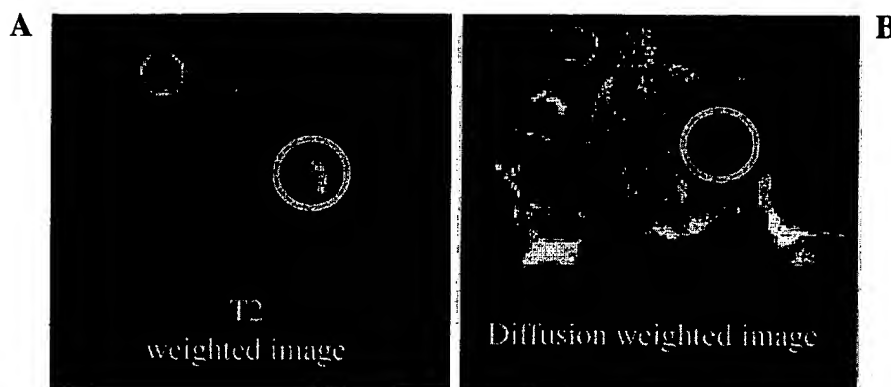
T2-weighted and diffusion-weighted images. Comparison of a T2-weighted image (A), showing hyperintensity of the damaged area, with a diffusion-weighted image of the same slice (stimulated echo, TR/TE = 3000/40.6, four averages, $G_d = 50$ mT/m). (B). The damaged area in the diffusion-weighted image is defined by hypointensity. The images depict overlapping of the damaged area in both types of acquisitions.
